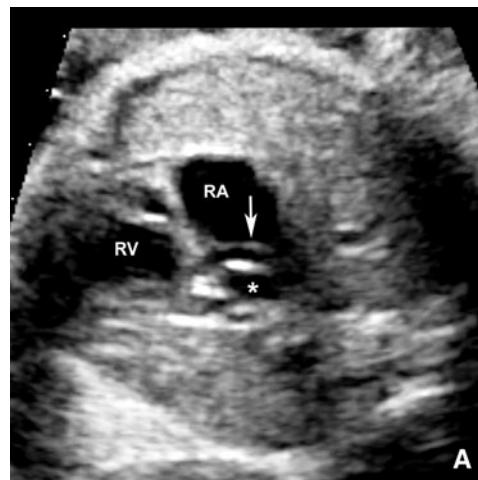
a Fetal echocardiogram performed at 22 3/7 weeks gestation demonstrating a four-chamber view of the fetal heart with a separate chamber located in the left atrium (asterisk) that is distinctly separate from the atrial septum (arrow). Also noted are severe left ventricular hypoplasia and mitral atresia. b Spectral Doppler of the pulmonary veins showing a restrictive flow pattern with elevated systolic peak
